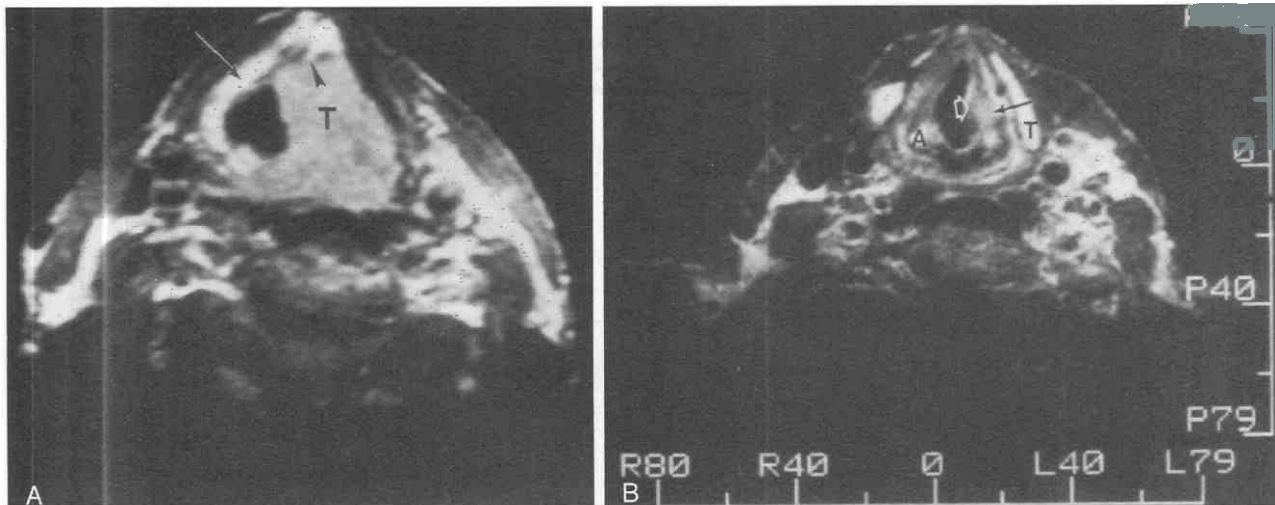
Supraglottic tumor with paraglottic spread into the lateral edge of the true cord. *A*, Axial slice through the supraglottic level shows the tumor (T). Note the interface of tumor with fat in the preepiglottic space (arrowhead) and the normal paraglottic fat (arrow) on the opposite side. *B*, Axial slice at the level of the cord shows a small amount of tumor (arrow) prying its way between the thyroid cartilage (T) and the thyroarytenoid muscle (TAM) (open arrow). This is at the true cord level below the level of the ventricle. A, arytenoid. (B, From Curtin HD: MR and CT of the larynx. In Thrall JH [ed]: Current Practice of Radiology, 3rd ed. St. Louis, Mosby-Year Book, 1994.)
